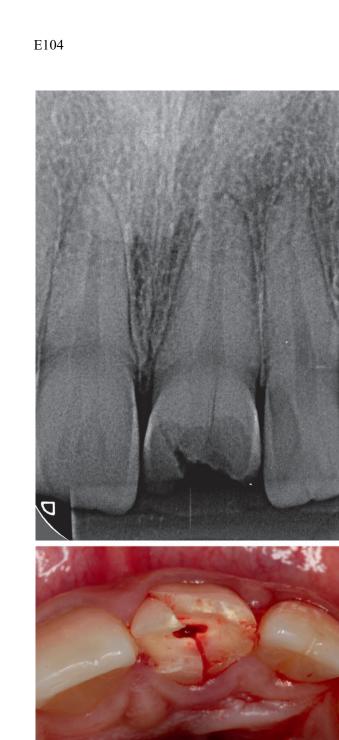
Periapical radiograph of the fractured tooth. Figure 4. Clinical aspect of the fragment still stuck to the gum fibers.
